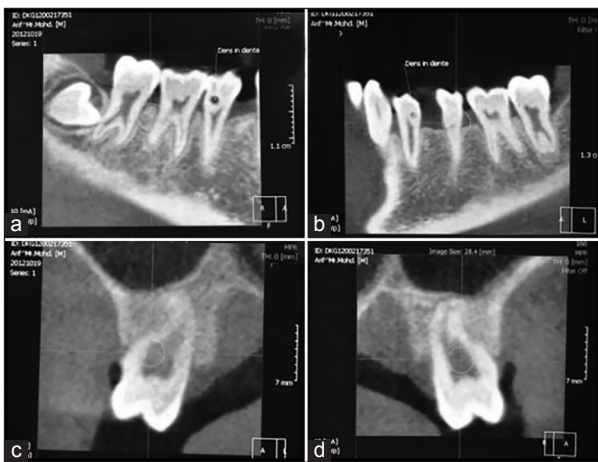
Cone-beam computerized tomography parasagittal section shows the dense invagination involving 34, 45 and taurodontism in relation with 47 (a), 37 (b), 17(c), 27 (d)
